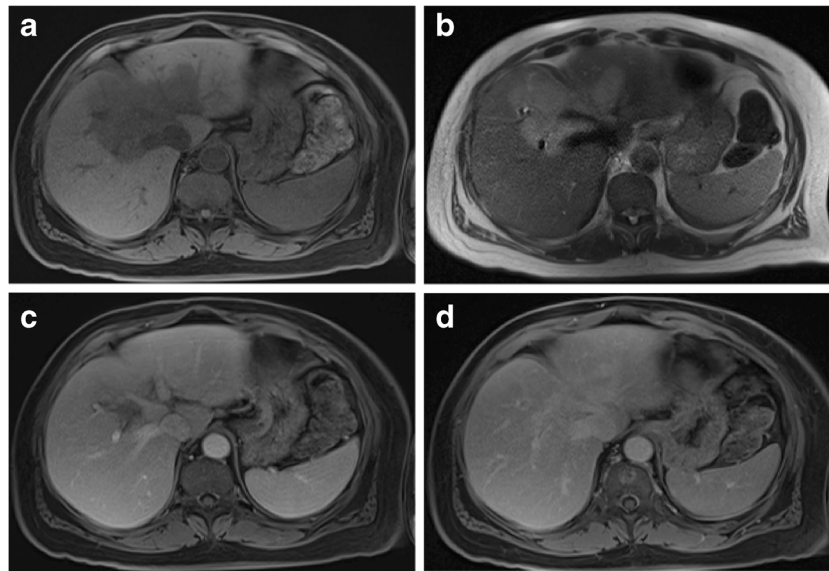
Primary hepatic lymphoma in a 60-year-old male. Transverse T1-weighted fat-suppressed three-dimensional (3D) gradient echo (GRE) (a), T2-weighted single-shot echo train spin echo (b), post-gadolinium fat-suppressed T1-weighted late hepatic arterial phase (c) and equilibrium
